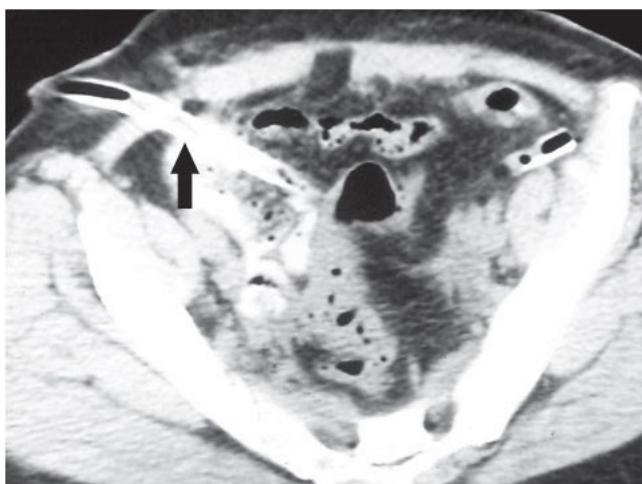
Postoperative Computed Tomography of the abdomen showing chylous ascites and the drainage tube (arrow)
